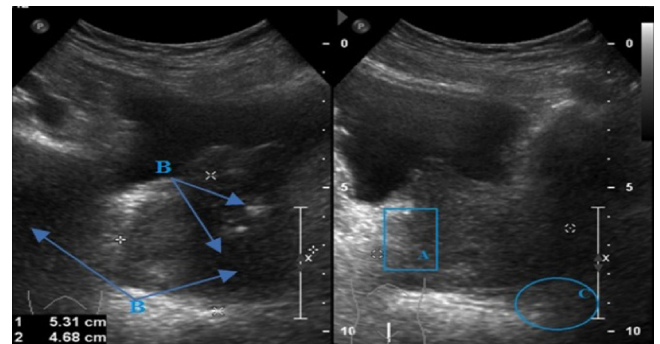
Prostate ultrasound image describing different challenges in segmentation.
